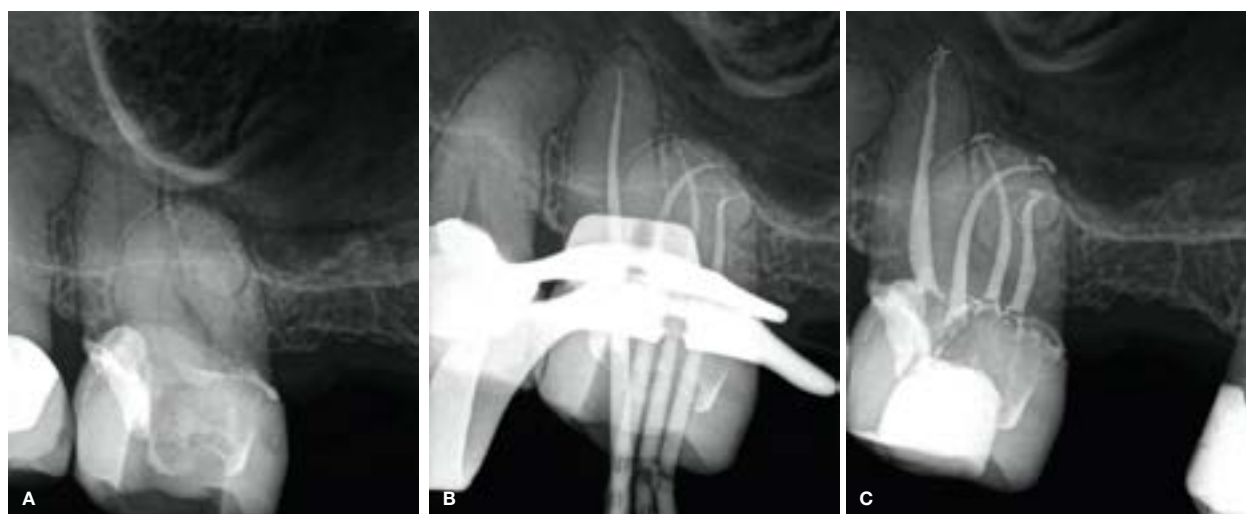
(A) Preoperative periapical radiograph revealed very narrow and calcified root canal systems. (B) Cone-fit radiograph to confirm the fit of the four size 20/07 gutta-percha points; (C) Final result after root canal obturation.
